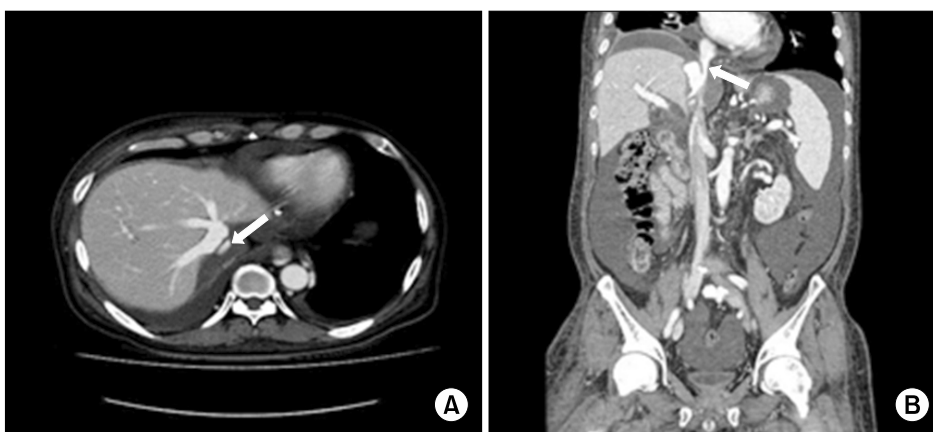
This abdominal computed tomography scan of the patient performed 6 weeks after deceased donor liver transplantation shows stenosis of the suprahepatic vena cava (arrows). (A) Axial view. (B) Coronal view.
